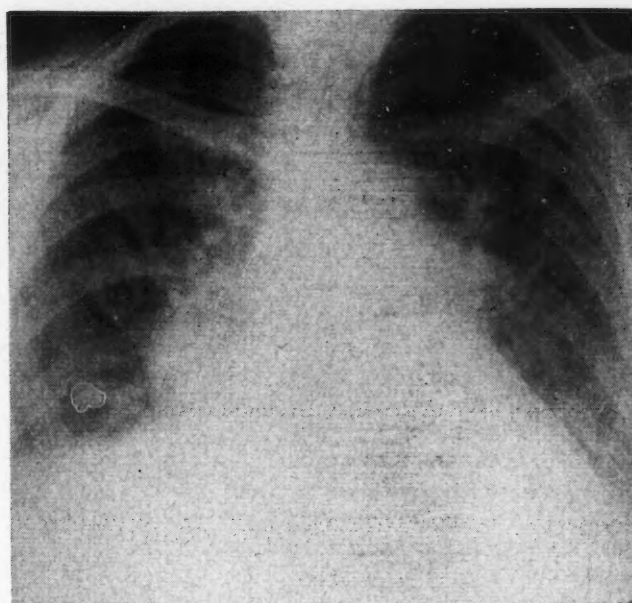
Chest radiograph (October 18, 1958), 12 hours after admission, indicates generalized cardiac enlargement and pulmonary congestion. There is a density in the right lower lung field consistent with a pneumonic consolidation.
